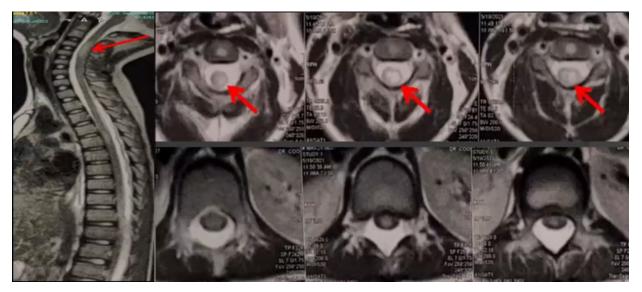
Spinal MRI showing T2 hyperintensity over the levels T5, T11-T12 (red arrow)
